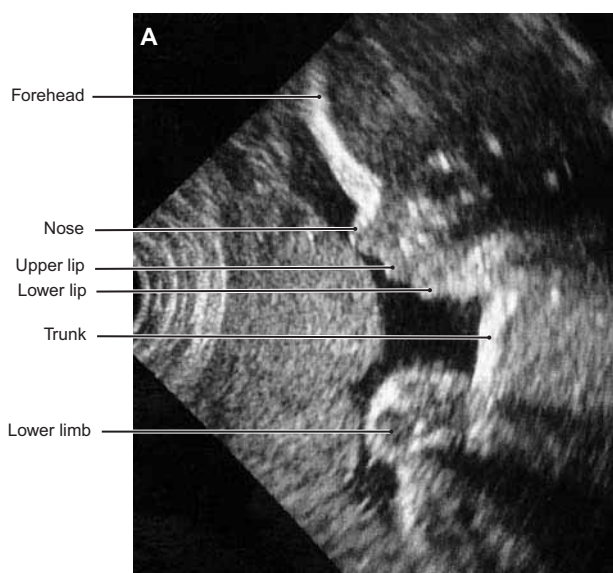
Sonogram of Uterus during 28th Week of Pregnancy
